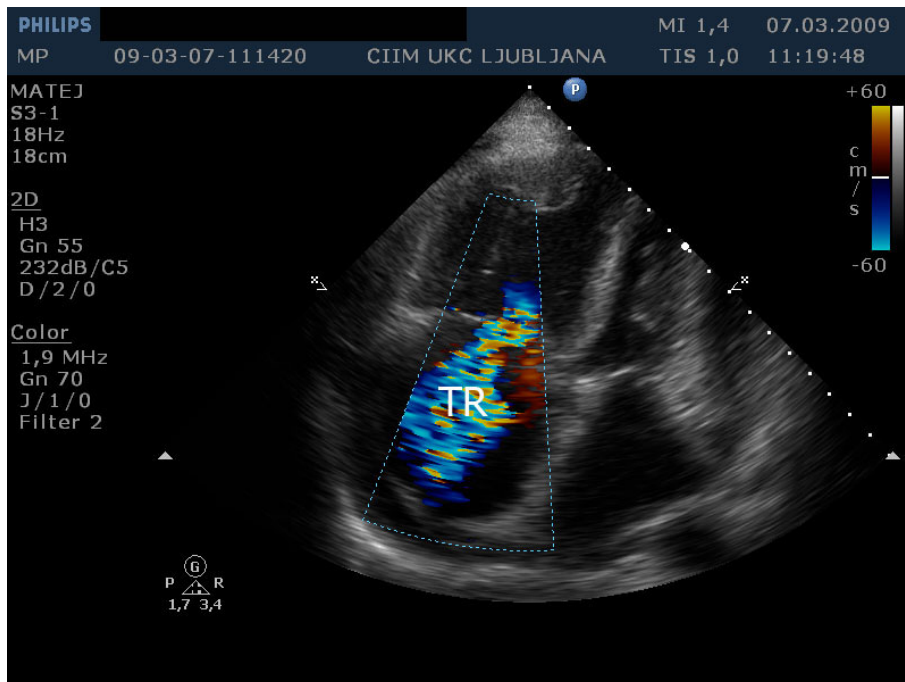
Transthoracic echocardiography from apical four chamber view shows massive tricuspid regurgitation (TR).
